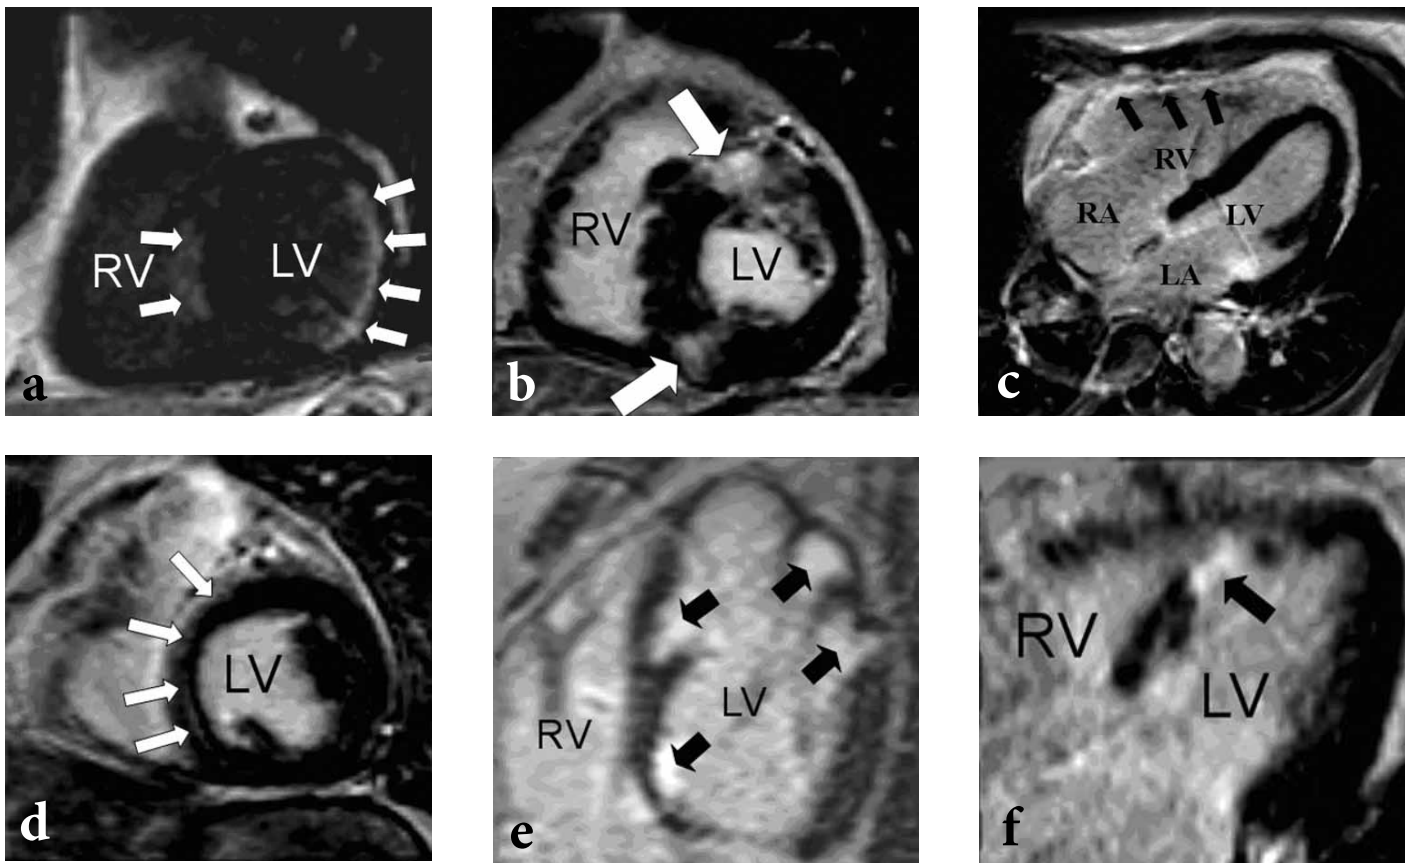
Inversion-recovery gradient echo MRI sequences, 10 minutes after the administration of 0.1 mmol/kg gadolinium-DTPA, may help differentiate between: (a) ischaemic cardiomyopathy (septal and subendocardial posterolateral infarcts); (b) hypertrophic cardiomyopathy (scarring at the junctions of right and left ventricles); (c) arrhythmogenic right ventricular cardiomyopathy (right ventricular fibrosis); (d) idiopathic dilated cardiomyopathy (midwall fibrosis); (e) infiltrative cardiomyopathies (cardiac sarcoidosis); and (f) systemic vasculitides (Churg Strauss Syndrome). LV = left ventricle; RV = right ventricle; LA = left atrium; RA = right atrium. Images courtesy of Dr Jan-Peter Smedema.
